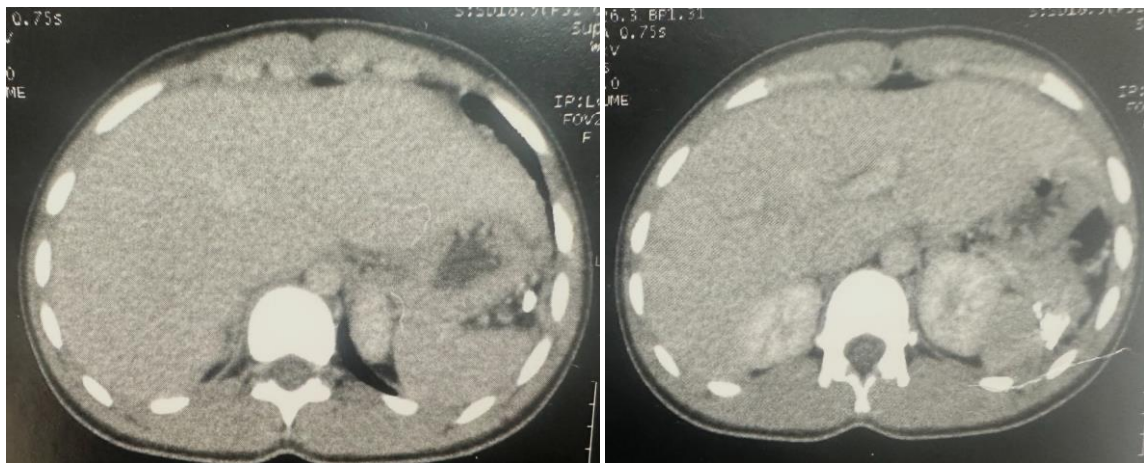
A 1 month post operative abdominal CT scan performed and showing the resolution of fluid accumulation previously affecting the lower pole of the splenic remnant, as was the resolution of left pleural effusion. A thorough review of the imaging data reveals that the splenic remnant appears to be normal, both in terms of parenchymal characteristics and vascular structures
